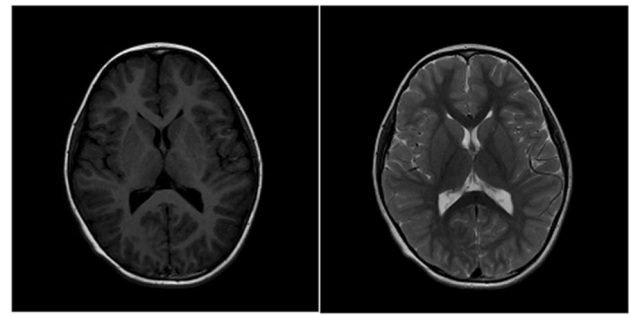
Brain MRI showed no abnormality
